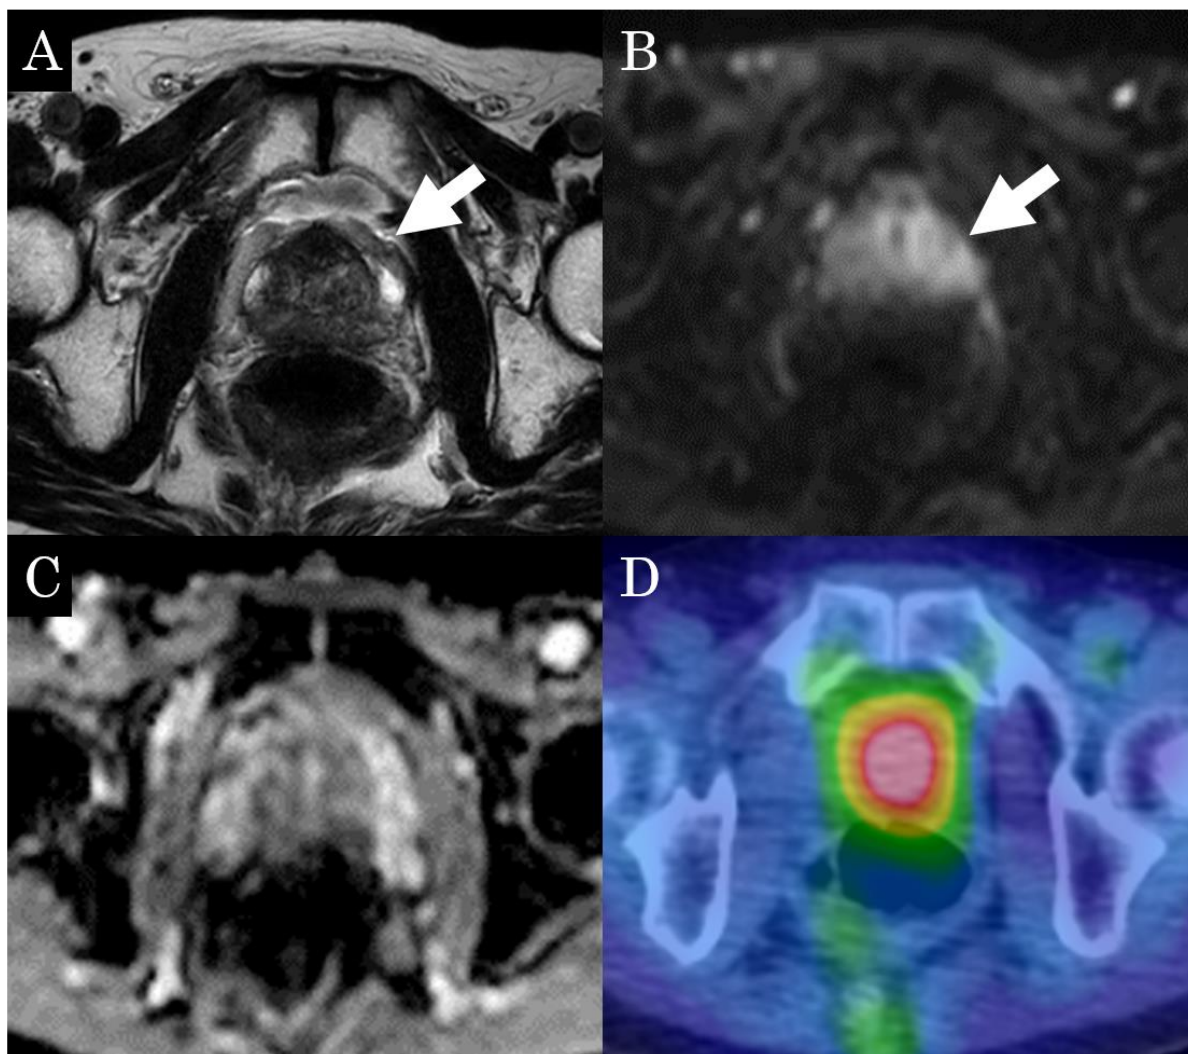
An MRI showed low signal intensity on T2WI (A, arrow) and mild high signal intensity on the diffusion-weighted image (B, arrow), suggesting prostatitis. The corresponding area shows heterogenous signal intensity on apparent diffusion coefficient map (C). A ^{67}Ga SPECT/CT shows high accumulation in the prostate (D).
